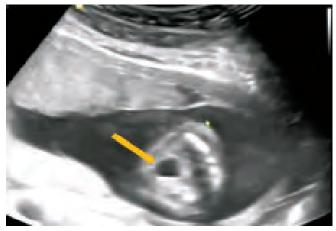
2D ultrasound image showing fetal bladder
